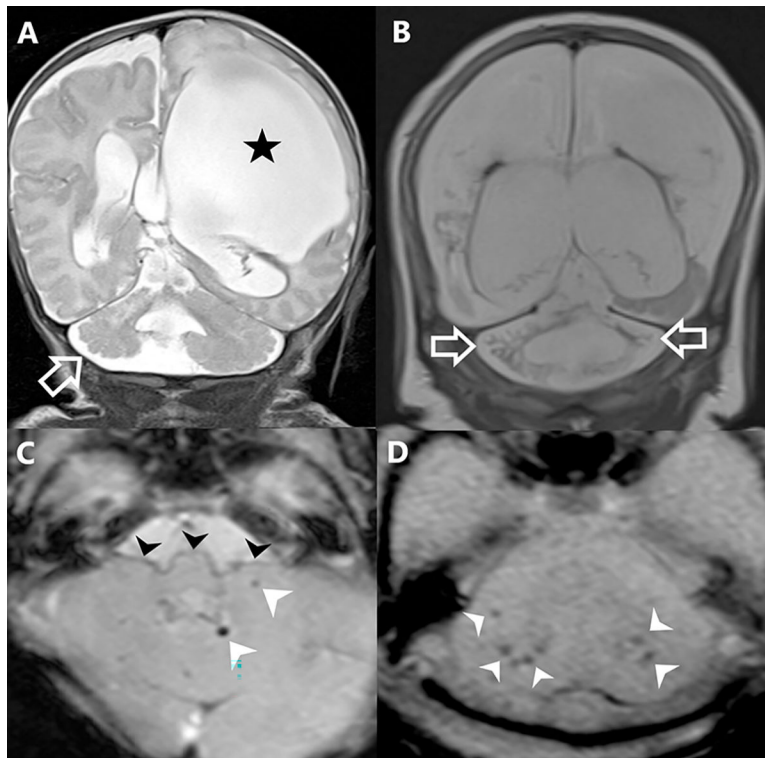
Cerebellar injury on MRI.
